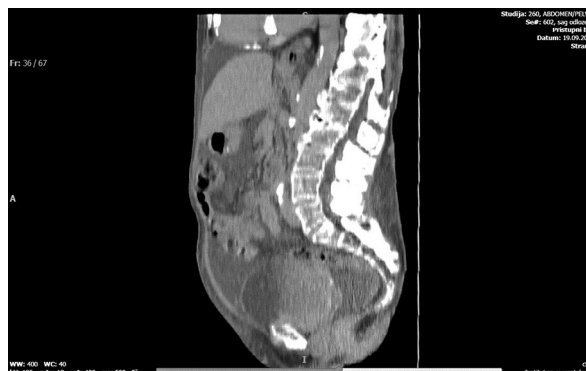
Multidetector computed tomography delayed phase – large ascites surrounding organs.
